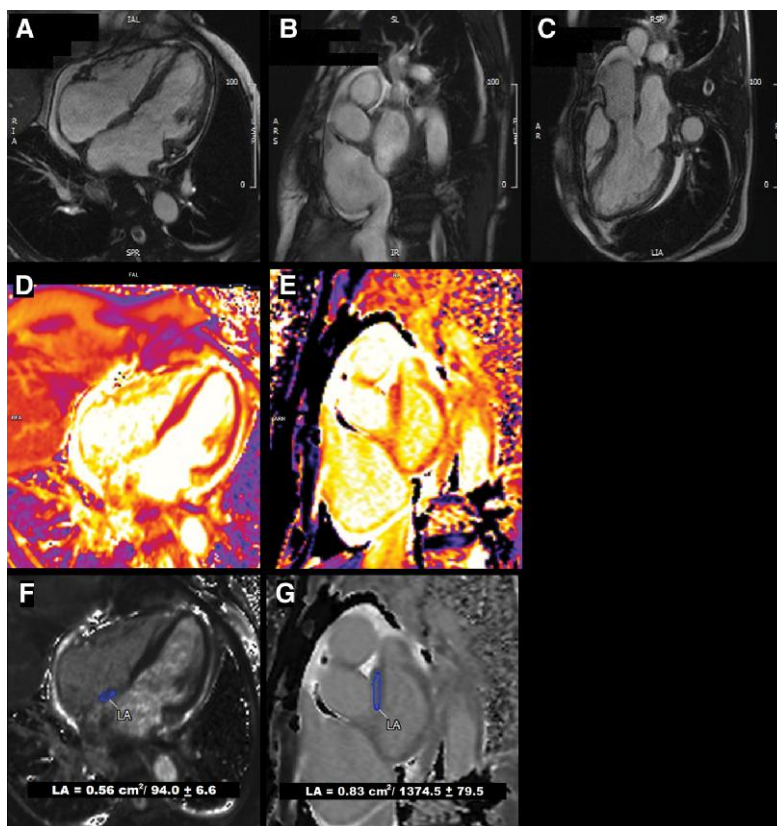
Cardiac magnetic resonance imaging before prednisolone treatment. Cardiac magnetic resonance imaging confirming left atrium dilatation with extensive wall thickening. Mapping sequences revealed fibrosis suggestive of pathological inflammatory activity of the left atrium. (A) Cine sequence four-chamber view. (B) Cine sequence short axis view. (C) Cine sequence three chamber view. (D) T2 mapping four-chamber view. (E) T1 mapping short axis view. (F) T2 mapping four-chamber view with left atrial region of interest. (G) T1 mapping short axis view with left atrial region of interest.
